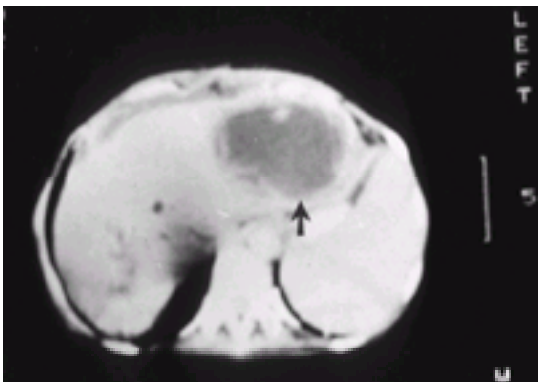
CT scanning indicates a liver abscess (arrow) at left hepatic lobe.
